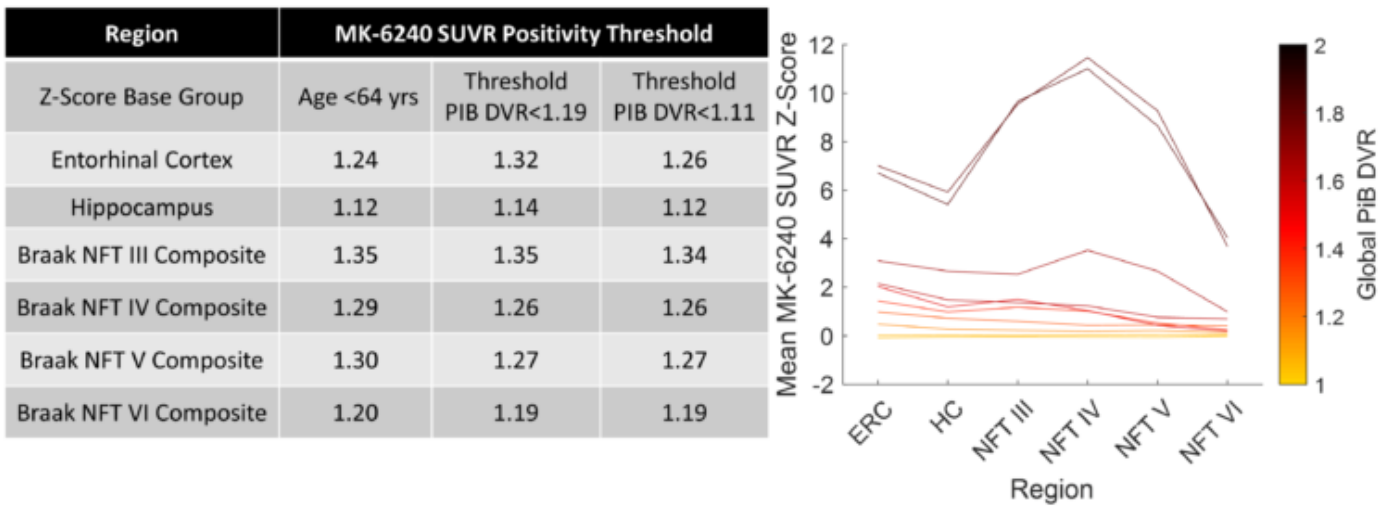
Left: Comparisons of regional MK-6240 positivity thresholds using the mean plus two standard deviations of MK-6240 SUVR for each region with z-scores established using younger participants, and PIB(-) participants using conservative and more liberal PIB(+) thresholds. Right: MK-6240 SUVR Z-scores using persons under age 64 were used to compare regional MK-6240 SUVR for varying levels of PIB DVR. The results indicated that those with lower PiB DVR values showed higher MK-6240 binding restricted primarily to early Braak NFT regions, whereas those with higher PiB DVR showed higher MK-6240 binding in all regions.
